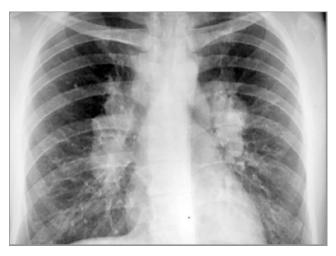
Chest X-ray PA view showing bilateral hilar shadows, lobulated (also subcarinal shadow) suggestive of lymphadenopathy. Possible sarcoidosis.
